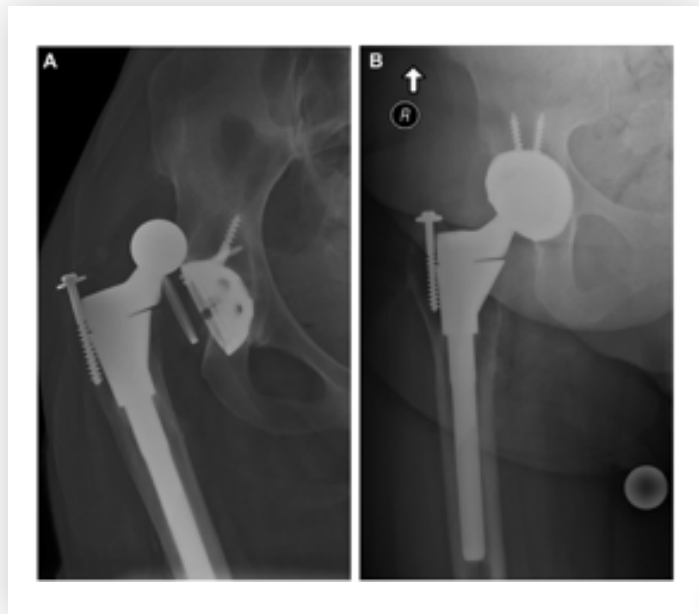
A) Radiograph demonstrating a 45-year-old woman with recurrent pain and instability following revision to a constrained liner and, B) the same patient status post revision to MDM acetabular components without pain or dislocation at 3-year follow-up.
